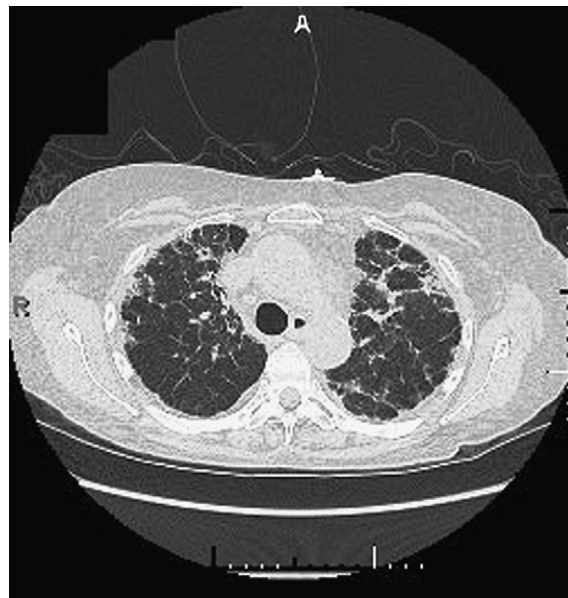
CT scan showing resorption of air after 3 days of treatment with high concentration oxygen therapy.
